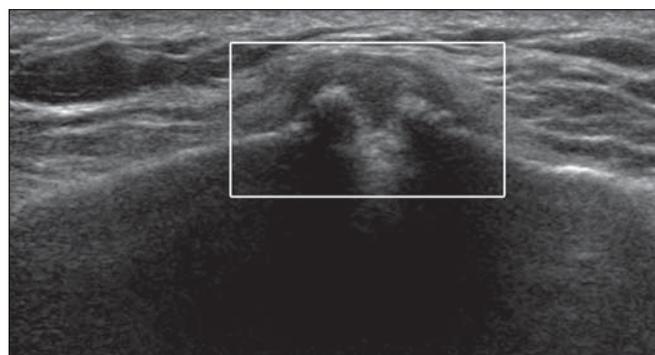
53-year-old man with asymptomatic acromioclavicular osteoarthritis. Ultrasound image of acromioclavicular joint (box) shows osteophyte formation and cortical irregularity of articular surface. Clavicle is on left side of image and acromion on right.
